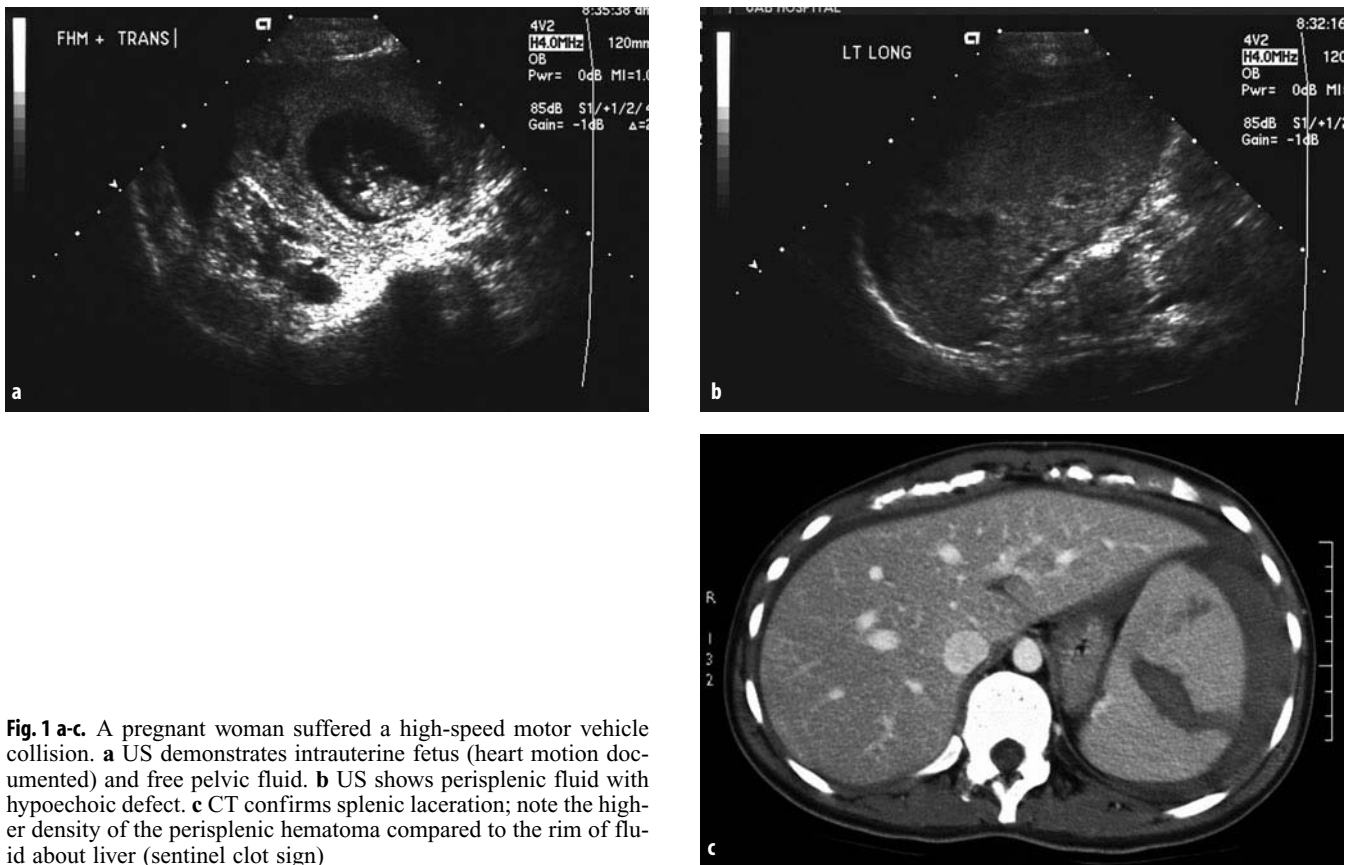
a-c. A pregnant woman suffered a high-speed motor vehicle collision. a US demonstrates intrauterine fetus (heart motion documented) and free pelvic fluid. b US shows perisplenic fluid with hypoechoic defect. c CT confirms splenic laceration; note the higher density of the perisplenic hematoma compared to the rim of fluid about liver (sentinel clot sign)
